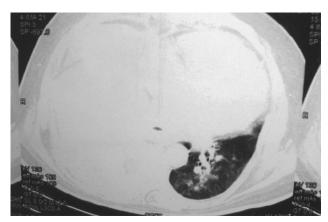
CT chest (lung phase) showing pulmonary parenchymal nodules and massive right pleural effusion.
